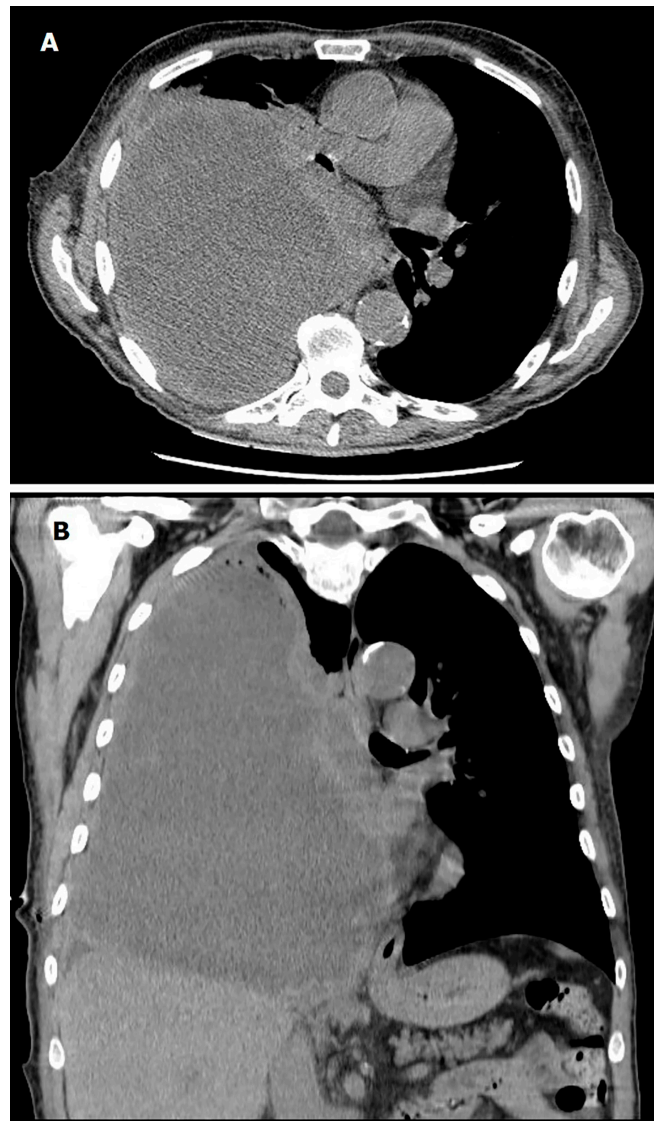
Non-contrast chest-CT at admission revealing a giant pleural fluid collection with pleural thickening, suggestive of empyema, associated with total collapse of the right lower lobe and partial collapse of the upper and middle lobes. (A) Axial and (B) coronal views.
